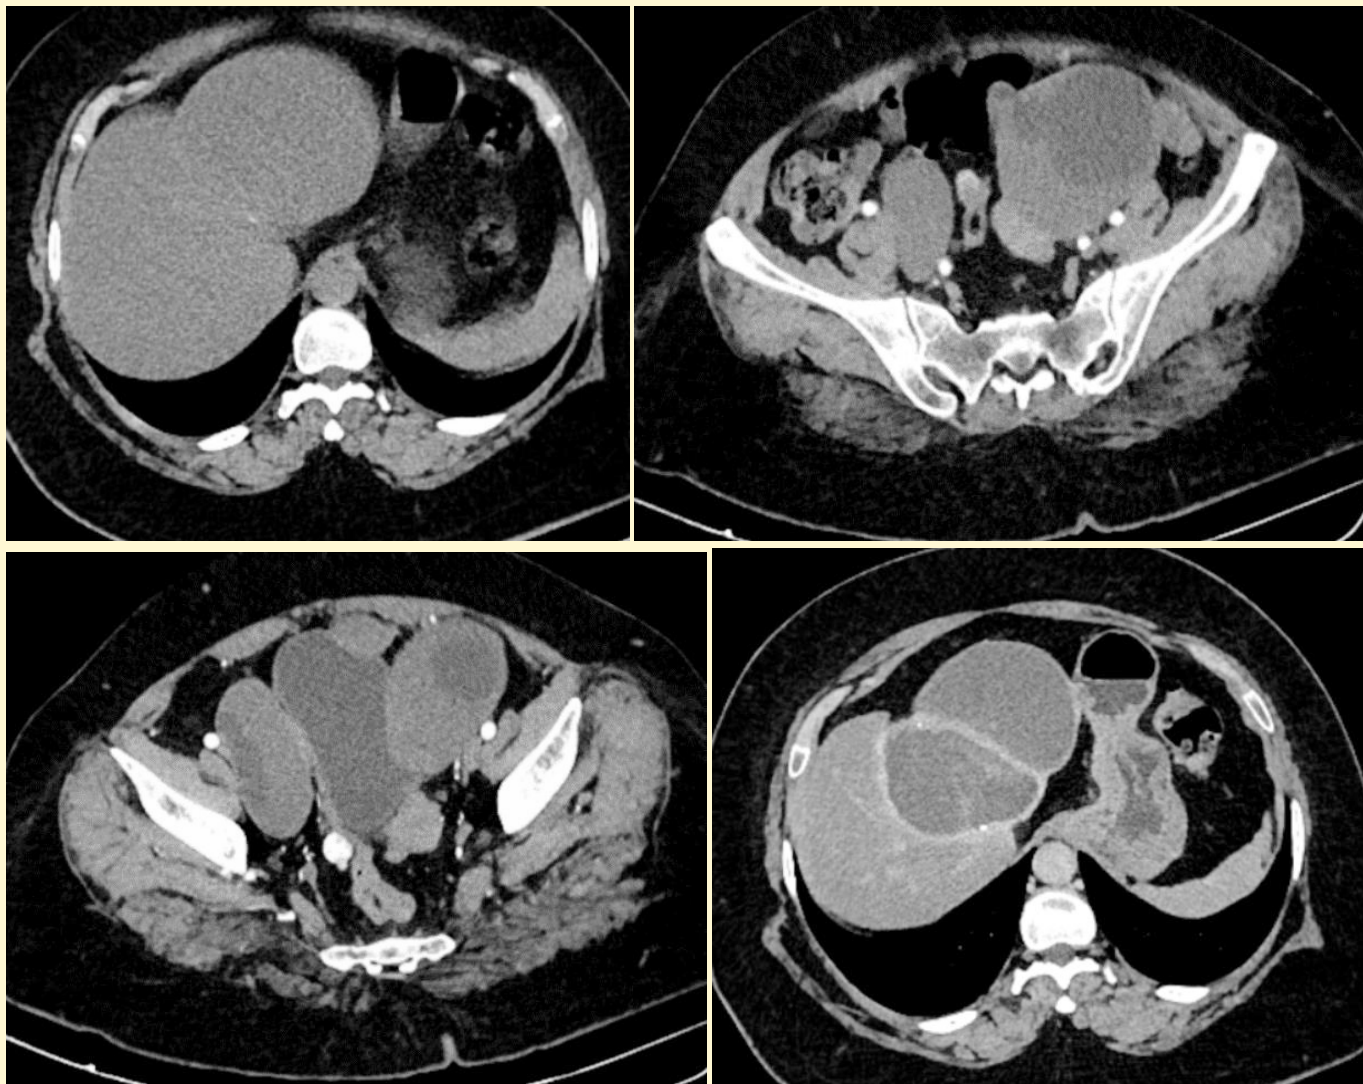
C) Axial sections of plain CT showing large hypodense cystic lesion with thin rim of calcification in left lobe of the liver. Fig D) Enhancement of walls and septations is evident on delayed phase post-contrast scan. Fig. E and F) Large ovarian cysts containing multiple daughter cysts of lower attenuation.
